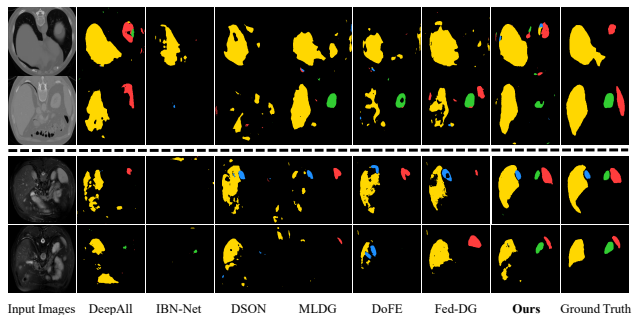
Visualization results on Multi-Organ segmentation task of different methods. First two rows: “MR to CT” task; Last two rows: “CT to MR” task.
